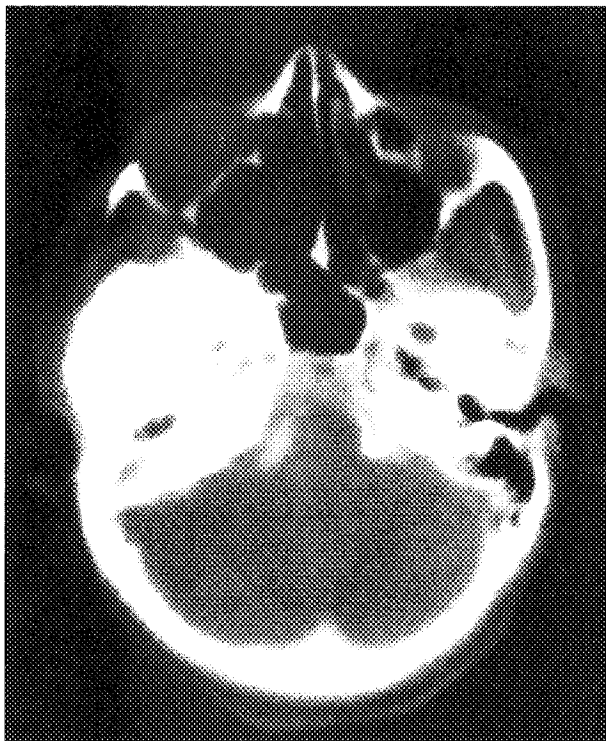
Early generation axial CT scan (case 7) that reveals sclerotic fibrous dysplasia that has led to thickening of the floor of the right middle cranial fossa and temporal bone from the parasellar and petrous apex region to the external auditory canal.
